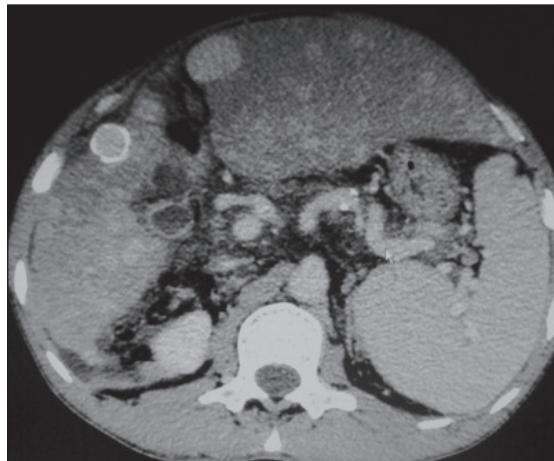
Contrast-enhanced computed tomography scan showing hypervascular lesions with marked homogeneous enhancement.
